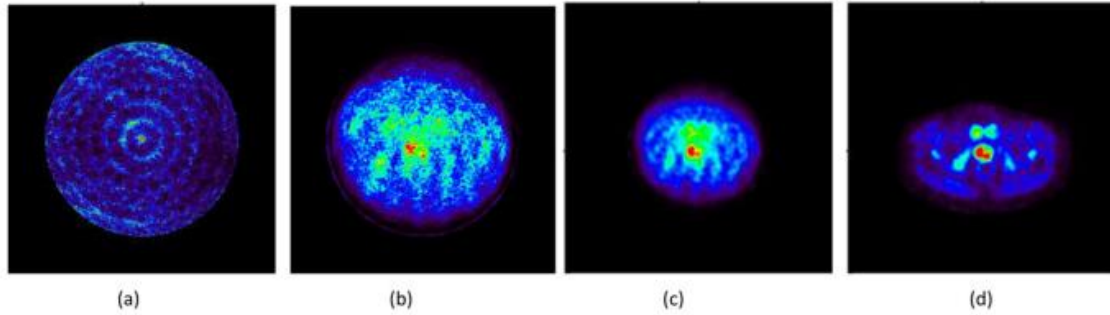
a) PROSPET patient image with no normalization b) Normalization but no attenuation c) Attenuation correction with the CT d) WB-PET image.
